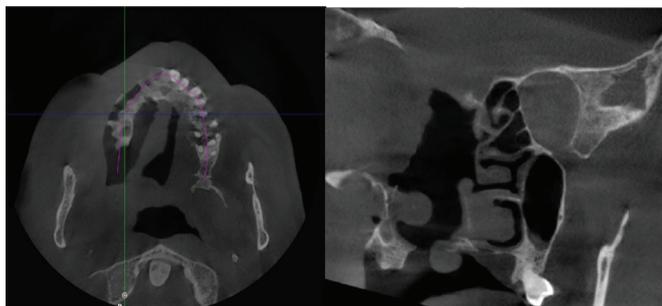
Cone beam computed tomography scan in (a) Axial section-mixed density lesion showing the sequestrum and the opening of the right maxilla (b) Coronal section-unilateral breach of maxillary sinus and floor of the nose with blocked sinus ostium
